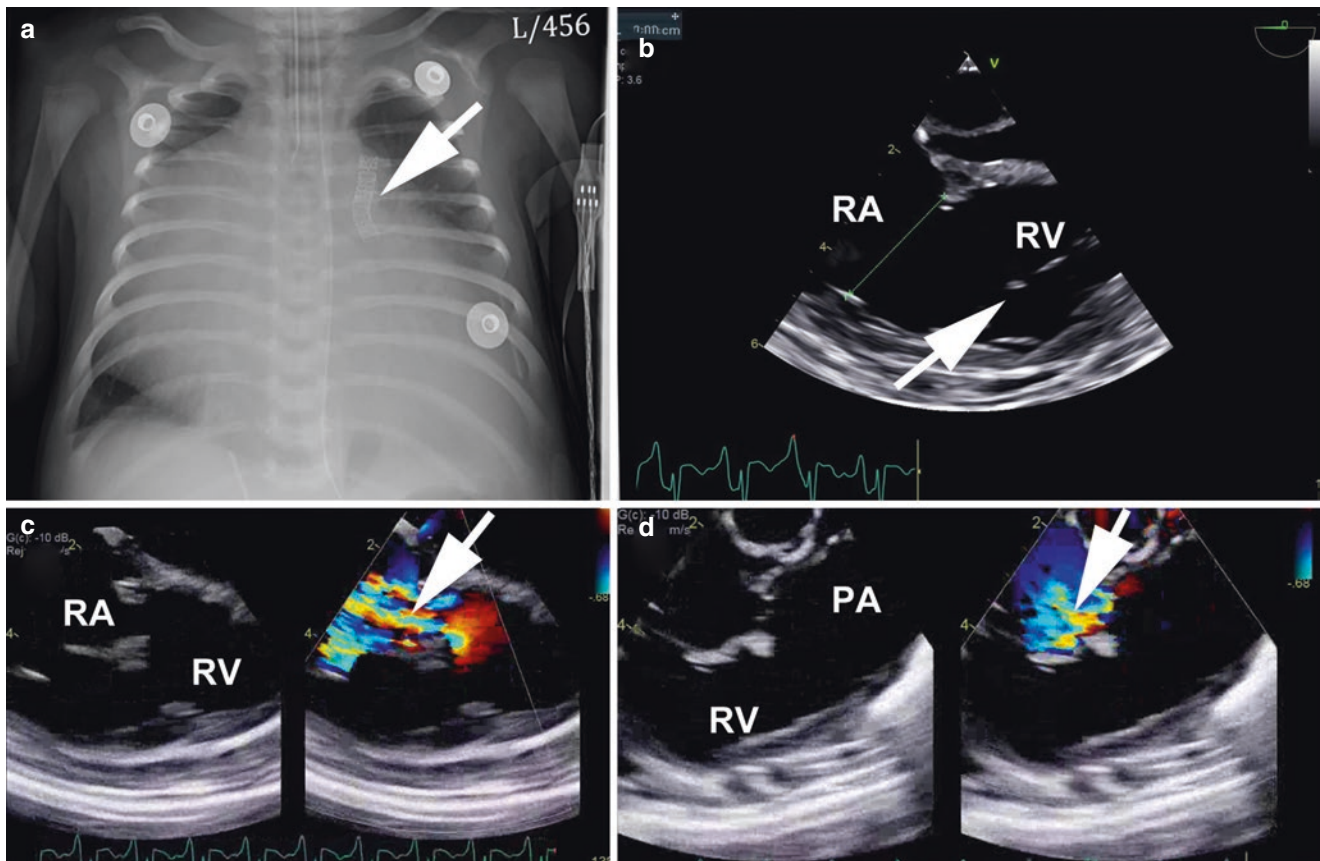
Panel a, chest radiograph of newborn with Ebstein anomaly showing severe cardiac enlargement and a stented ductus arteriosus (arrow). Panel b, transesophageal four-chamber view showing displaced tricuspid valve leaflets into the right ventricular (RV) apex (arrow) relative to the level of the valve annulus (line), and a moderate
